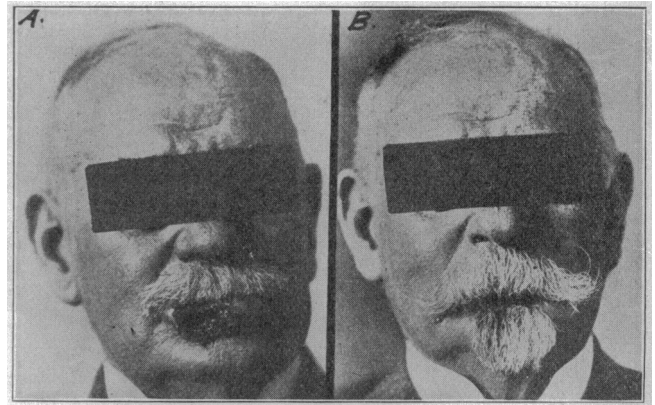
Epithelioma of the lower lip (A). Duration one year. Removed by electrothermic coagulation, Feb. 17, 1914, and followed by deep roentgenotherapy. (B) Thoroughly healed in about two months. Photograph taken July 27, 1914. Patient wearing, attached to his teeth, an artificial lip, to which is attached the beard.
